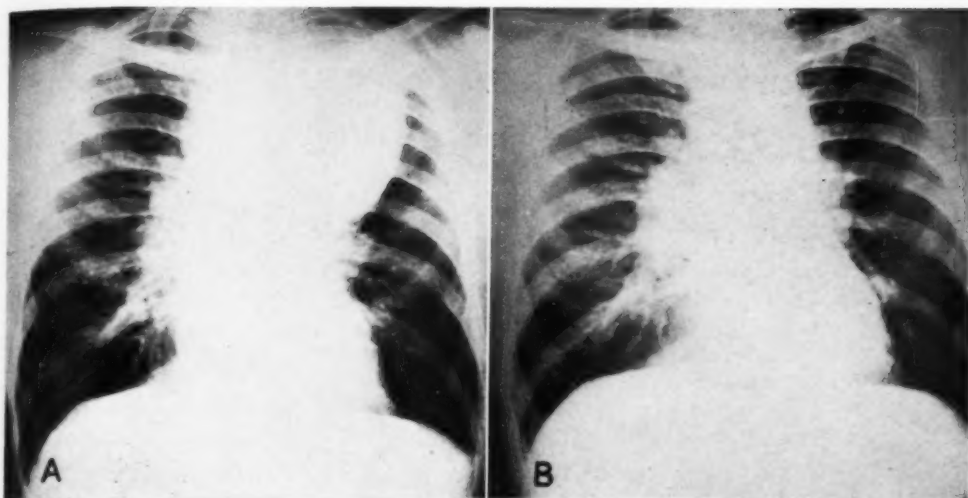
Hodgkin's disease. White male, age 26, with enlarged nodes in the right axilla and groin. A. Large mediastinal mass of uniform density and smooth borders and a slight nodular thickening of the right hilum. It is impossible to differentiate between the various forms of lymphoblastoma. The diagnosis was made on biopsy of a cervical node. B. Four months later and after roentgen therapy there is considerable improvement. The appearance now closely resembles that seen in hyperplastic tuberculosis (sarcoid). This often is true in Hodgkin's disease during periods of remission following therapy.
